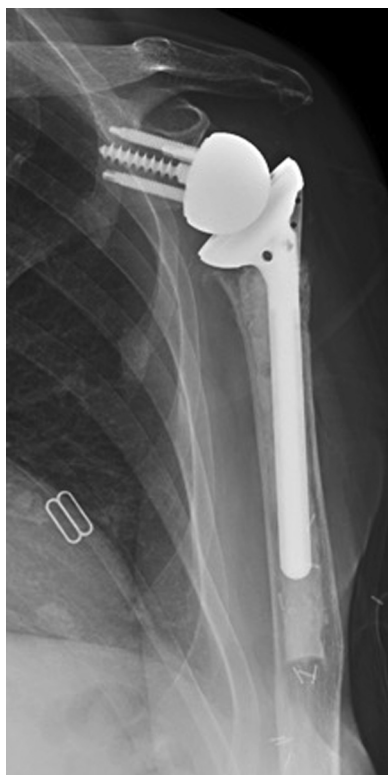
The postoperative anteroposterior radiograph after index procedure showing intact reverse total shoulder arthroplasty.
